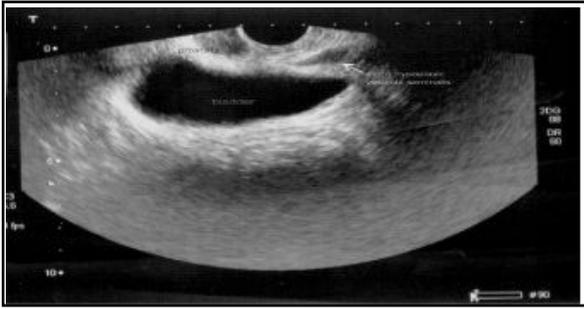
Transrectal ultrasonography (TRUS) shows no left seminal vesicle and right hypoplastic seminal vesicle with ovoid cystic shape (2.0x0.8cm).
